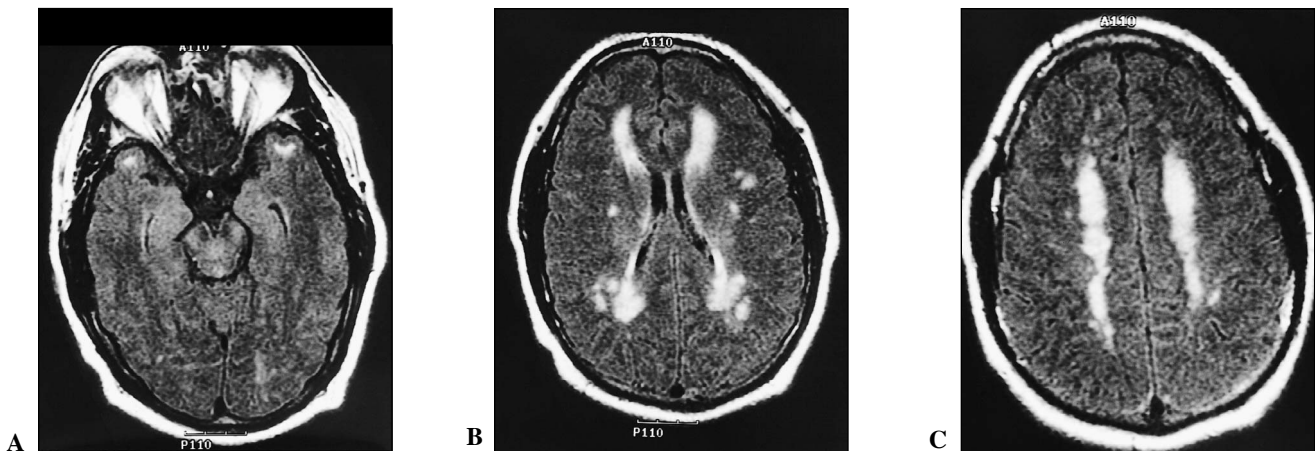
A-C, Axial FLAIR images in the symptomatic index case reveal abnormal patchy and confluent signal hyperintensities in the subcortical white matter of both temporal lobes (A), periventricular and subcortical white matter (B), and centrum semiovale (C).
